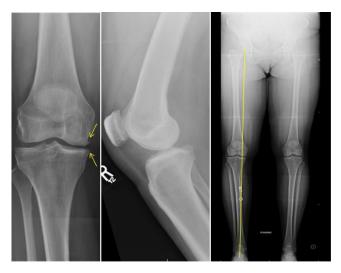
AP and lateral radiographs demonstrate mild medial joint line narrowing with early osteophytes. Mechanical axis passes medial to the center of the knee, which measured 5 degrees of varus (right).
